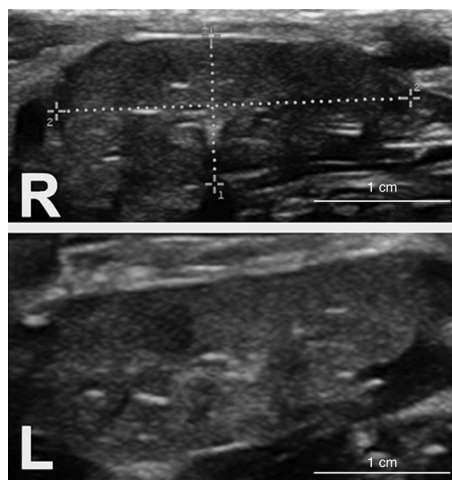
Ultrasound image of the right (R) and left (L) submandibular salivary glands in longitudinal axis showing bilateral abnormally diffused enlargement.
